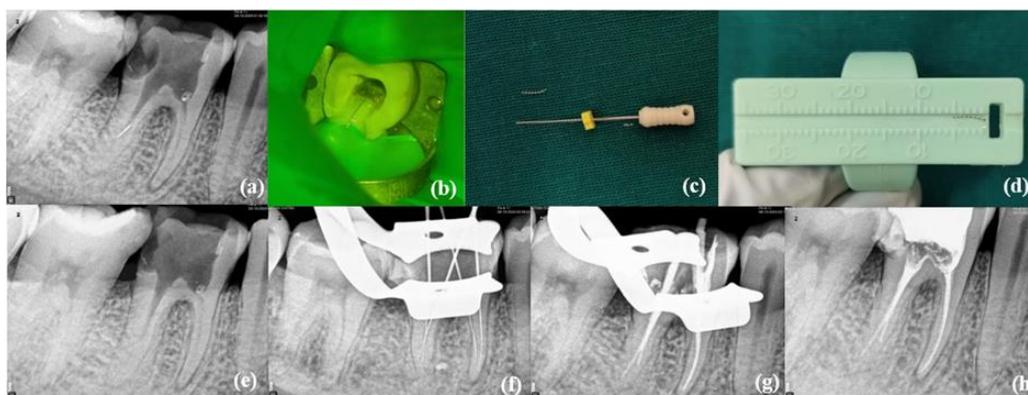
(a) 5 mm of separated instrument in the distobuccal canal irt 46; (b) Retrieved file under DOM; (c) Retrieved instrument; (d) Length of the retrieved instrument measured on endogauge; (e) Radiograph following retrieval; (f) working length determination; (g) Mastercone verification; (h) Obturation
